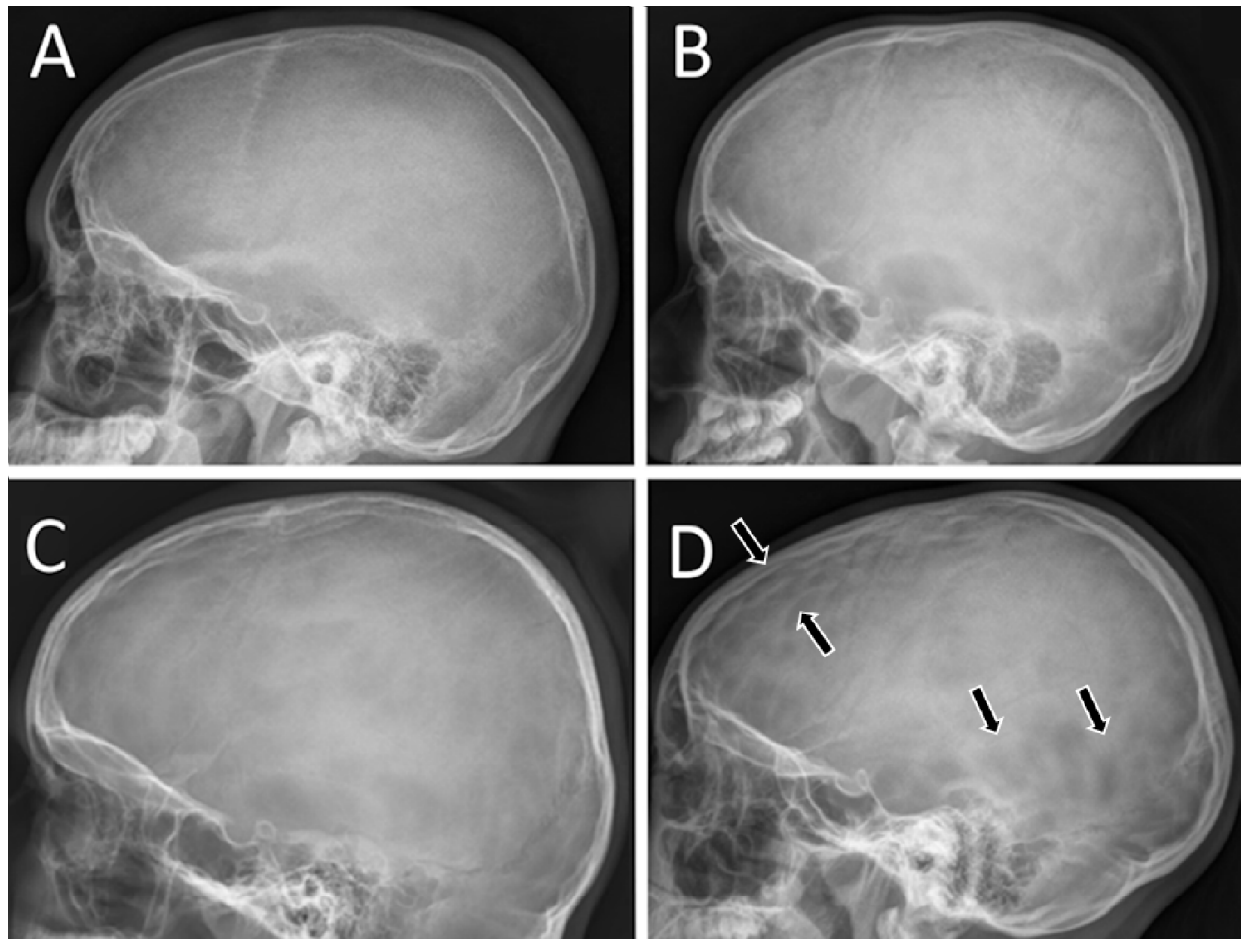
Representative examples of copper-beaten skull grades 0–3 on lateral cephalometric radiographs. A: Grade 0, no visible convolutional markings. B: Grade 1, few and shallow convolutional markings. C: Grade 2, moderate convolutional markings. D: Grade 3, extensive and prominent convolutional markings, indicated by arrows.
